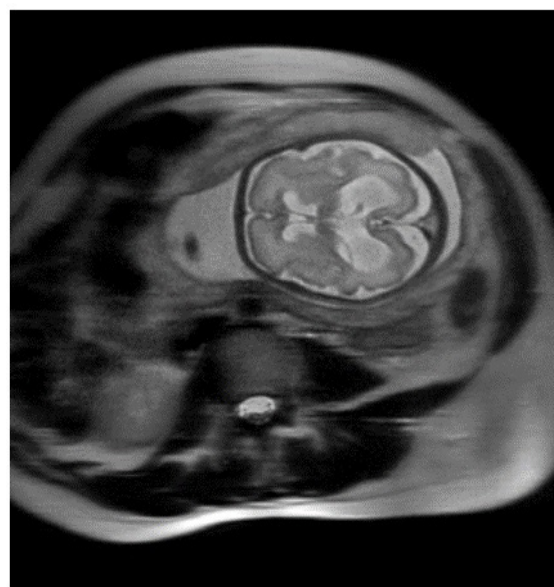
Case 2 – fetal MRI (32 Weeks' GA). Sagittal and axial MR T2-W images in a 32 weeks'GA fetus show dolichocephaly and a large hyperintense mass inside a markedly ballooned torcular Herophili
